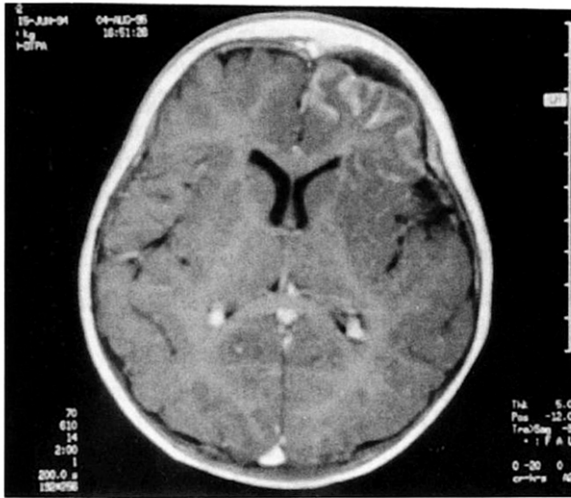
Gd-DTPA enhanced MRI showing atrophy in the left frontal lobe and enhancement of the gyral surface of the left fronto-parieto-temporal lobe.
